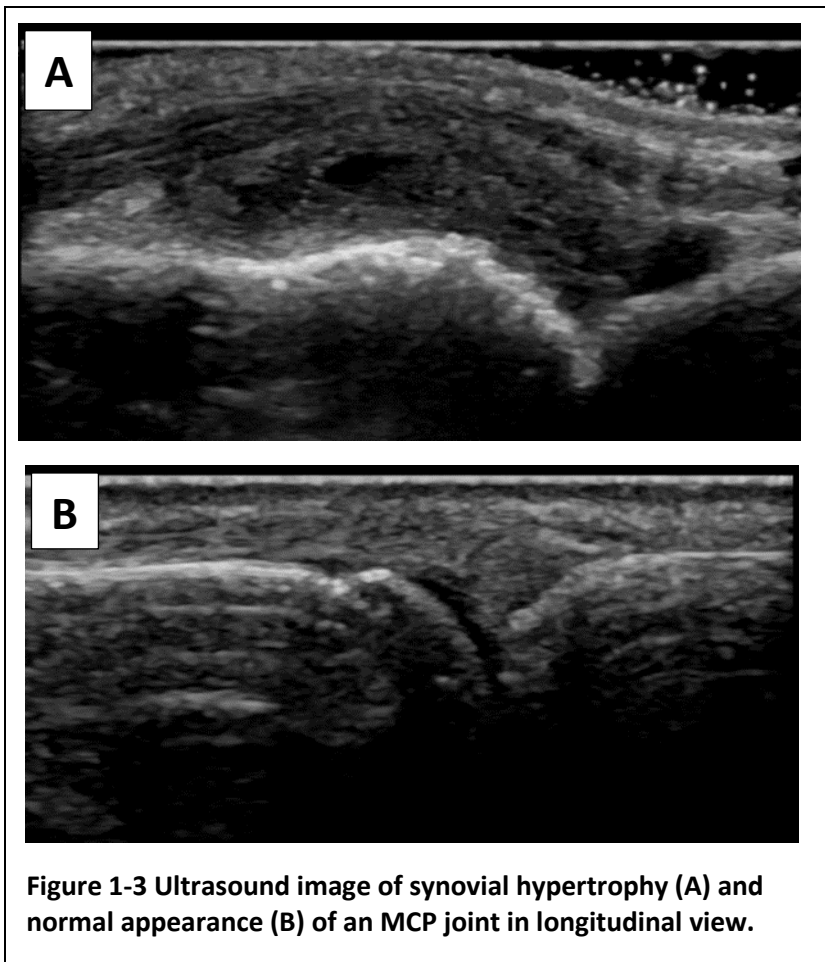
Ultrasound image of synovial hypertrophy (A) and normal appearance (B) of an MCP joint in longitudinal view.
